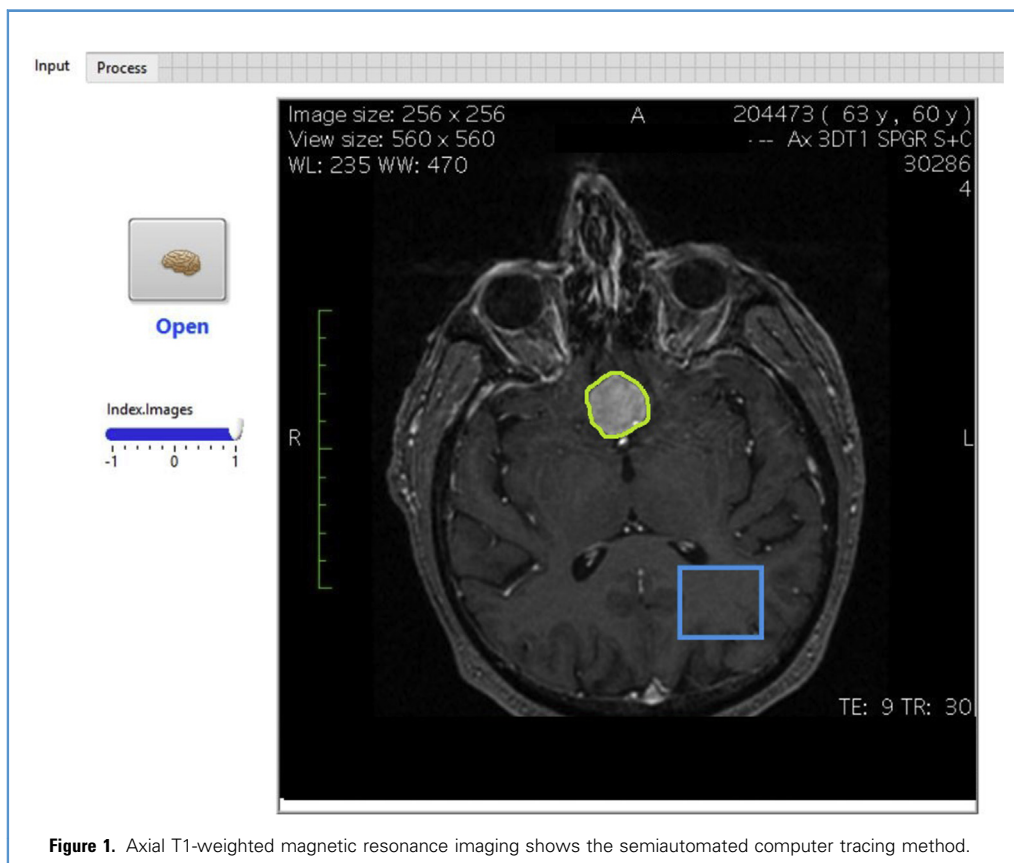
Axial T1-weighted magnetic resonance imaging shows the semiautomated computer tracing method.
